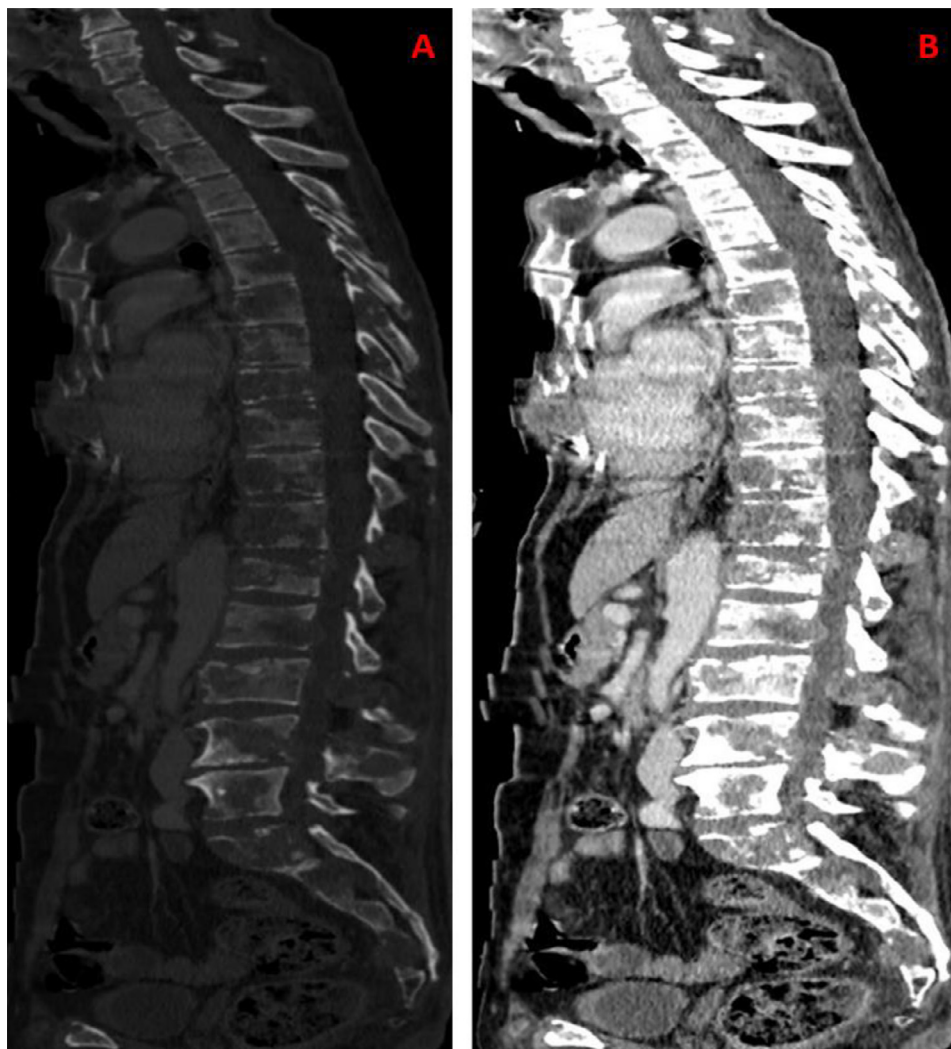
Computed tomography (CT) scan in sagittal spine reconstruction showed multiple osteolytic lesions in bone (A) and parenchymal windows (B).
